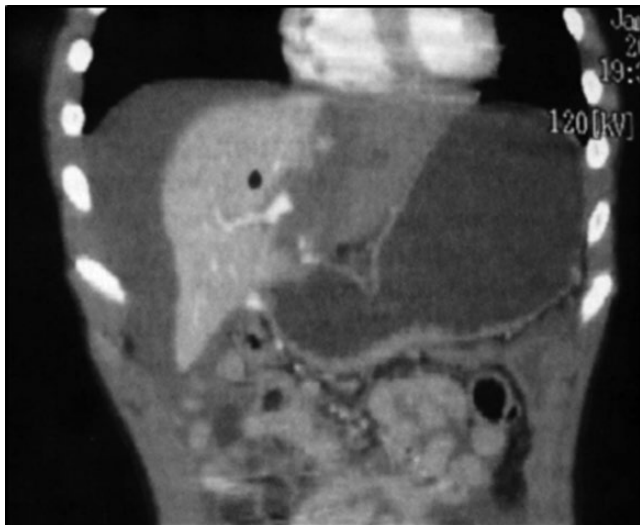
Coronal CT of a child after blunt abdominal trauma, showing hypoperfusion of the left liver, a “blush” of contrast indicating ongoing hemorrhage, and a large amount of fluid (blood) surrounding the liver. The stomach also appears to be dilated. Urgent laparotomy and resection of the almost completely avulsed left lateral segment was required in this case.
